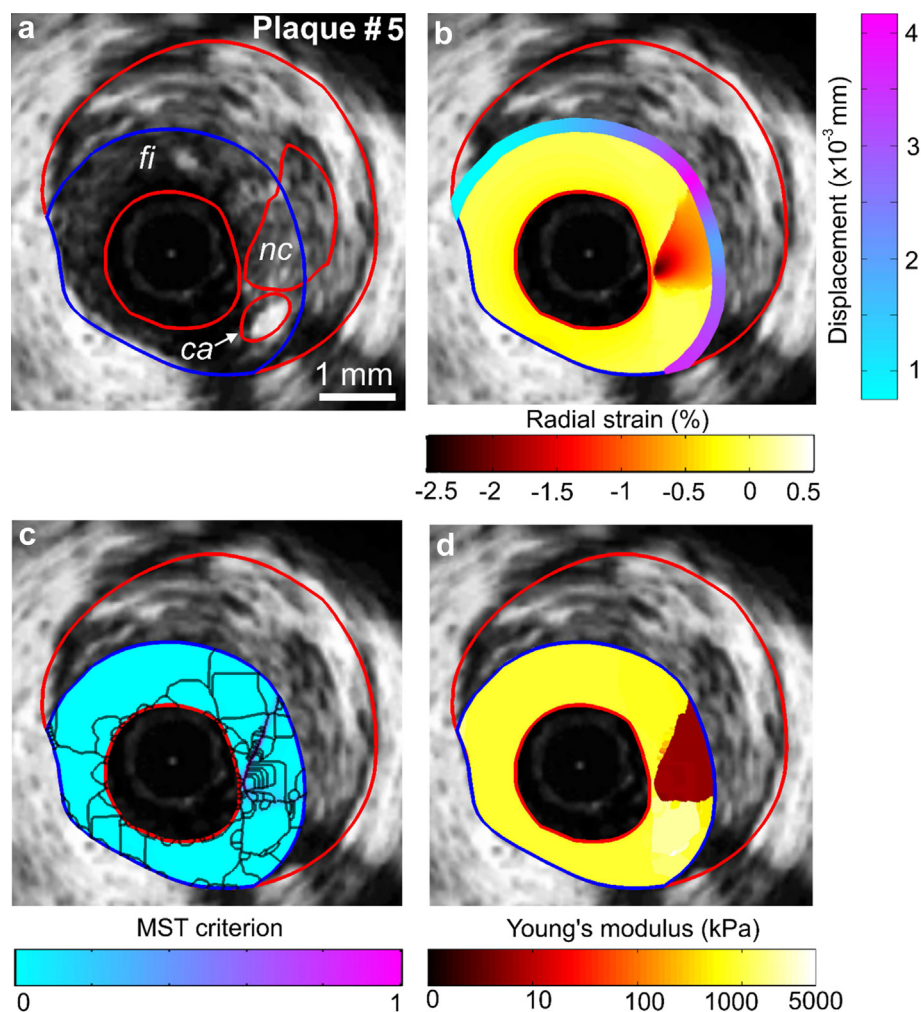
Performance of the proposed E-iMOD technique to detect a vulnerable plaque with a small, calcified inclusion adjacent to a necrotic core. (a) Intravascular ultrasound image of plaque #5 with plaque constituents (red contours). (b) Radial strain-elongogram and displacement applied on the intraplaque outer endoluminal boundary. (c) Spatial distribution of the normalized modified Sumi's transform criterion and extracted inclusions contours ($n = 150$). (d) Computed modulogram. nc = necrotic core; fi = fibrous region; ca = calcified inclusion.
